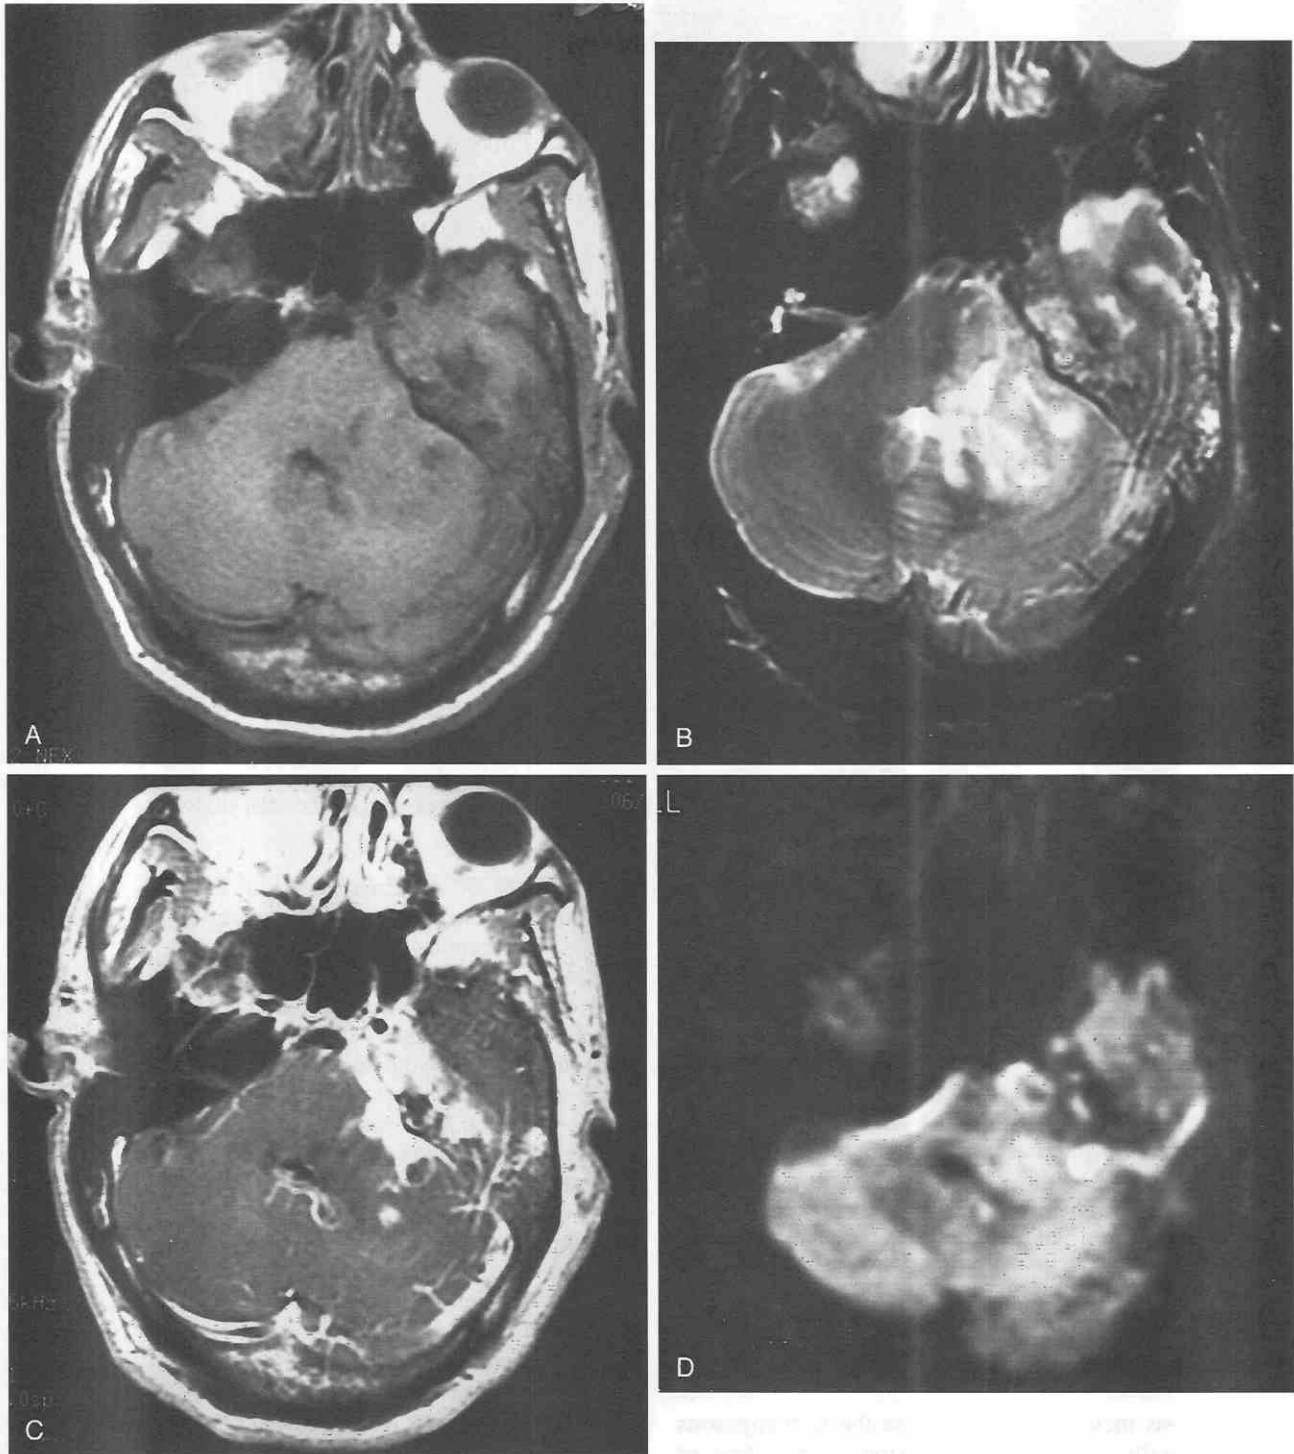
Mastoiditis, cerebritis, and abscess formation. *A*, T1-weighted image shows abnormal low signal intensity in the left temporal lobe, left brachium pontis, and left mastoid. *B*, T2-weighted image shows heterogeneous high signal intensity involving the left temporal lobe, left brachium pontis, and left mastoid. *C*, Gadolinium-enhanced image demonstrates abnormal enhancement involving the left temporal lobe, left brachium pontis, and left mastoid. Note the presence of a small ringlike enhancement in the posterior aspect of the brachium pontis. *D*, Diffusion-weighted image reveals a focal area of increased signal intensity, corresponding to the ringlike enhancement. This is consistent with restricted diffusion in an abscess.
